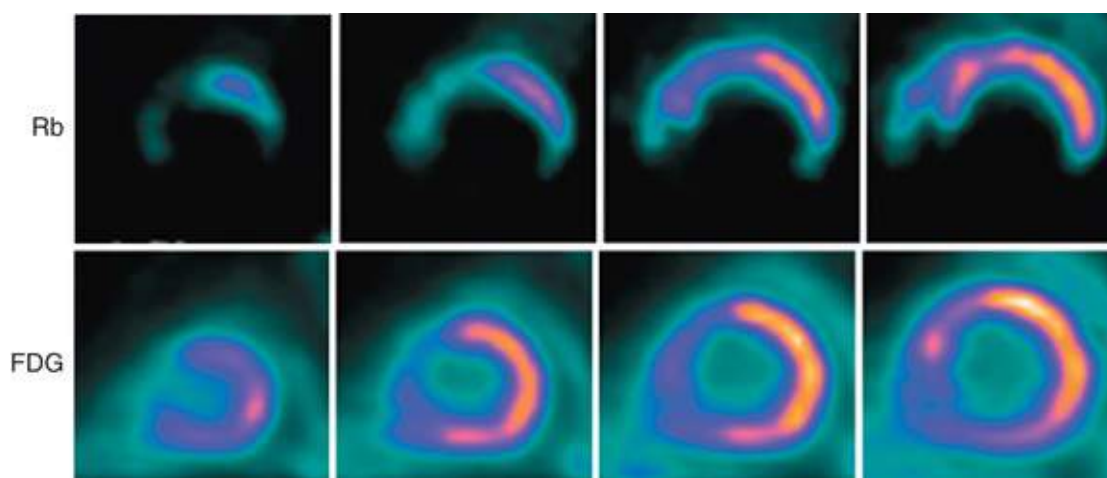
Assessment of viability by positron emission tomography (PET) imaging. Top row, Rubidium-82 (^{82}Rb) is used as a tracer of myocardial blood flow at rest in these short-axis images starting toward the apex (*left*) and moving toward the base of the heart (*right*). Myocardial perfusion is markedly decreased in the apical, inferior, inferolateral, and septal regions. Bottom row, ^{18}F -fluorodeoxyglucose (FDG) is used as a tracer of myocardial glucose metabolism. FDG uptake is enhanced relative to blood flow, demonstrating a pattern of perfusion-metabolism mismatch in most abnormally perfused myocardial regions, indicative of viable or hibernating myocardium. An exception is the anteroseptal region, which demonstrates a matched perfusion-metabolism pattern, indicative of nonviable or scarred myocardium. (From Taegtmeyer H, Dilsizian V. Imaging myocardial metabolism and ischemic memory. *Nat Clin Pract Cardiovasc Med* 2008;5[Suppl 2]:S42.)
